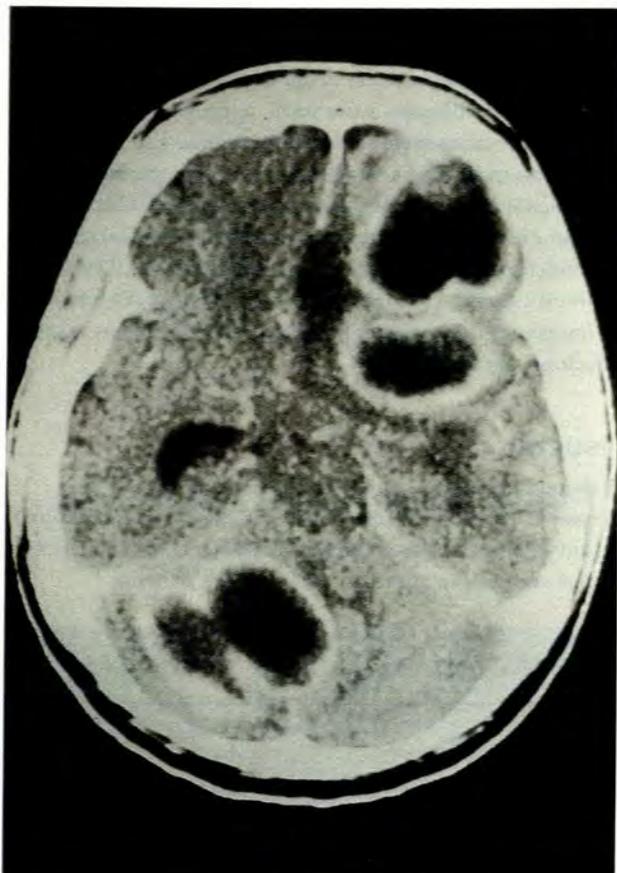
CT scan showing both supra- and infratentorial abscesses.
